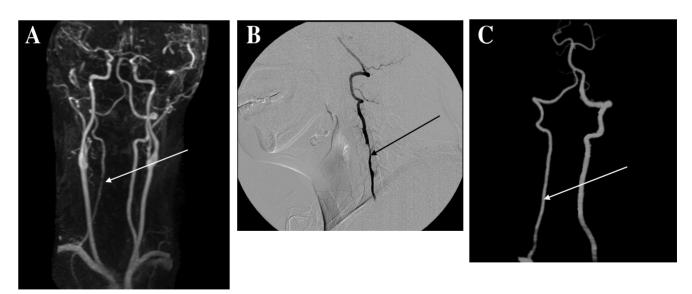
(A) Luminal stenosis of the right vertebral artery from the 4th cervical vertebra by magnetic resonance angiogram (MRA) study (white arrow). (B) Conventional angiography reveals focal segmental stenosis of the right extra-cranial vertebral artery around the 4th cervical vertebra level (black arrow), and right VAD with luminal narrowing. (C) After four months, computed tomography angiography (CTA) shows total resolution of the right VAD (white arrow).
